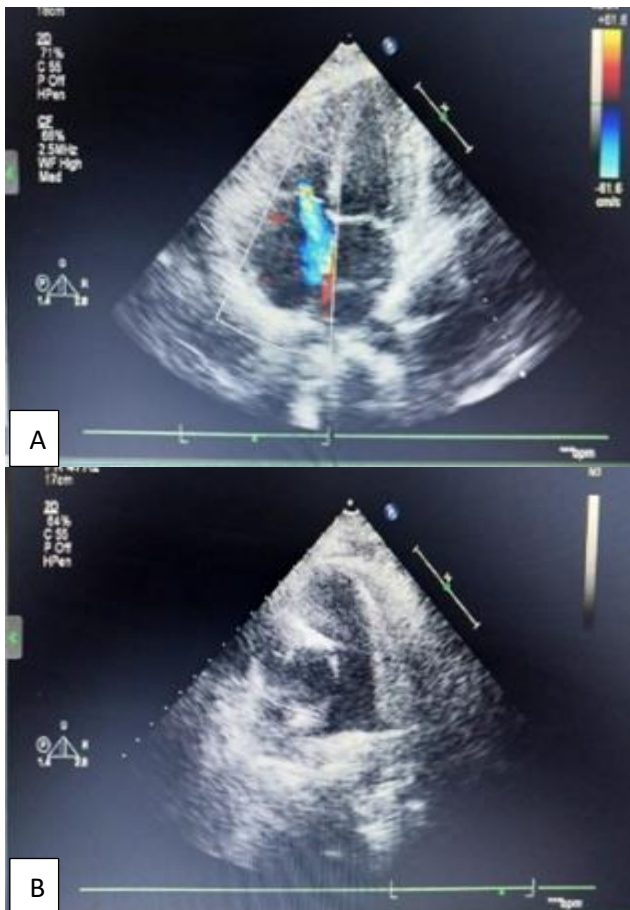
(A and B): Postoperative echocardiogram.
